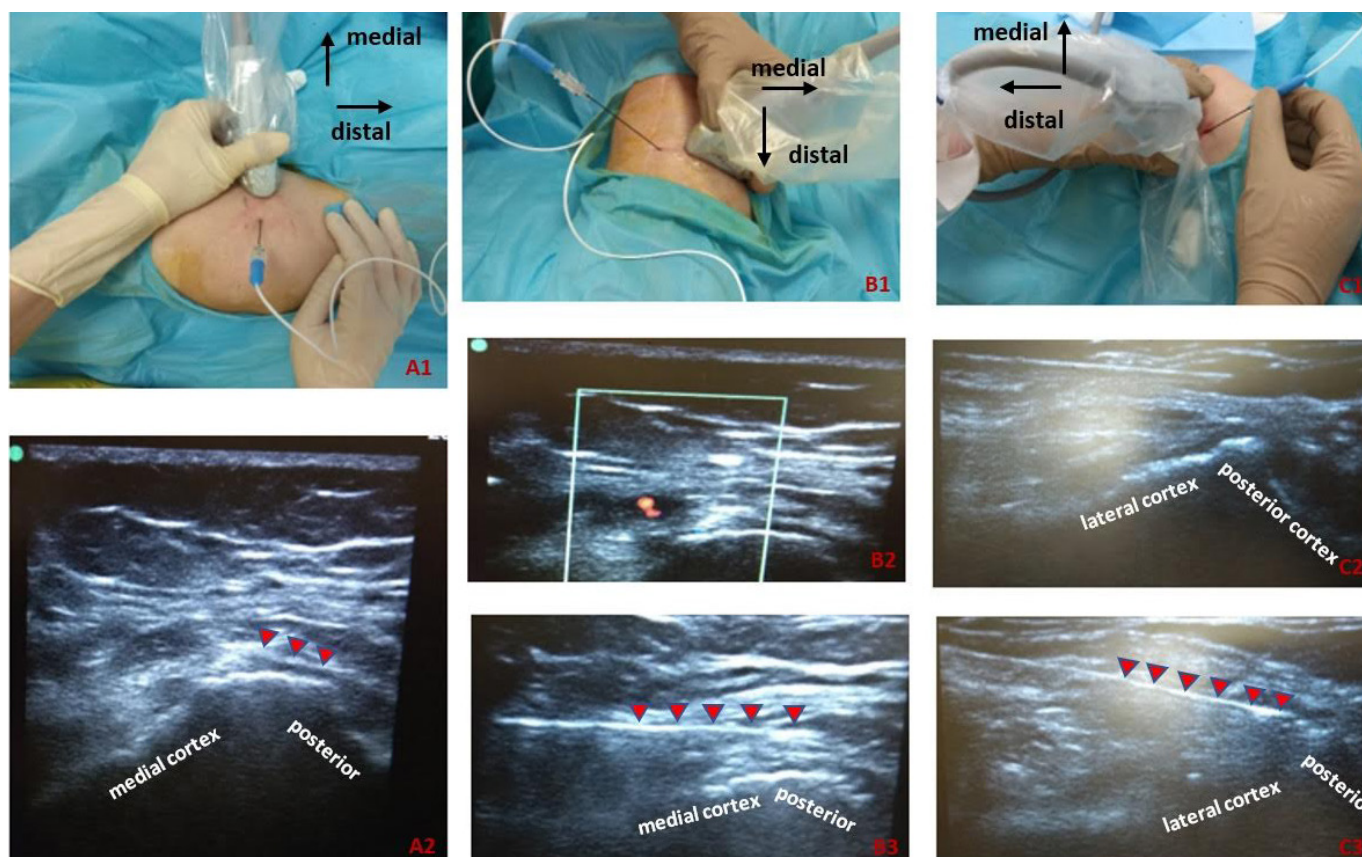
Ultrasound guided radiofrequency of the right knee. NOTE: red arrows indicating the needle position
